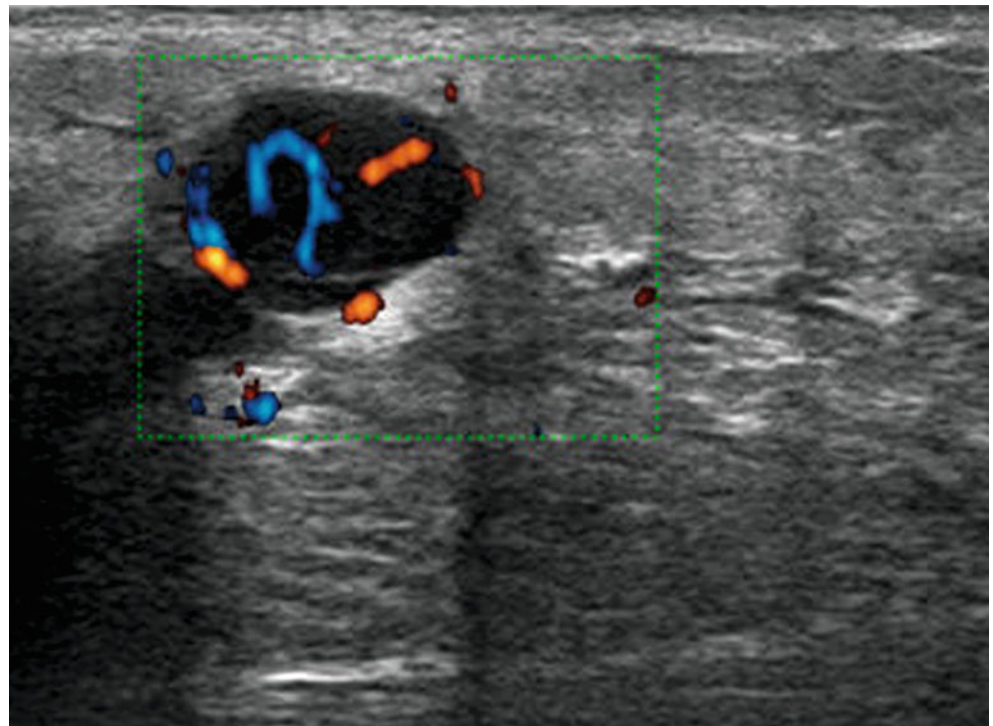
Seroma vs. metastasis. Directional power Doppler image. In pure B-mode the posterior enhancement of the echoes would be misleading for a diagnosis of seroma. However, the artificially written question mark, depicted here by power mode, easily leads to raise the diagnosis of a metastasis
